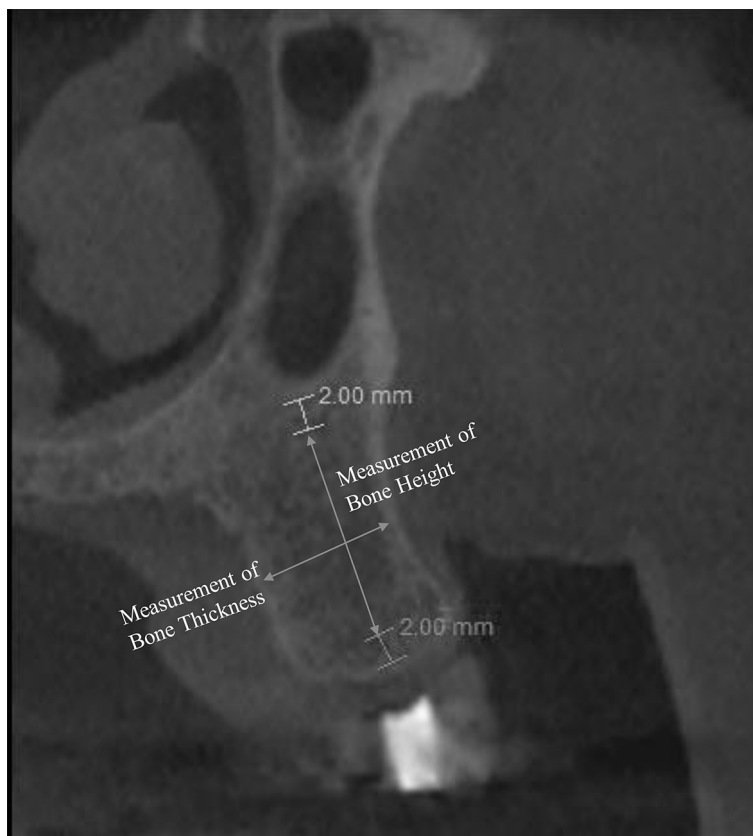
CBCT measurements of bone height and thickness.
